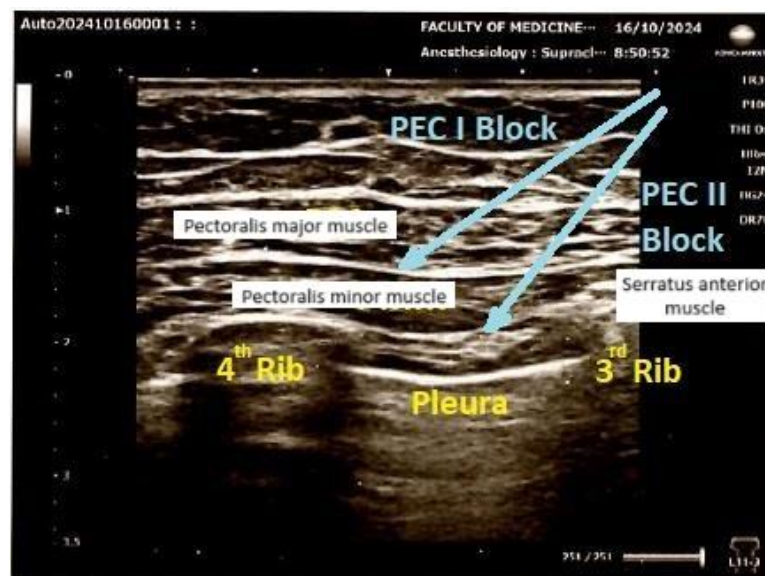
Sonographic anatomy of PECs-I and PECs-II block.
